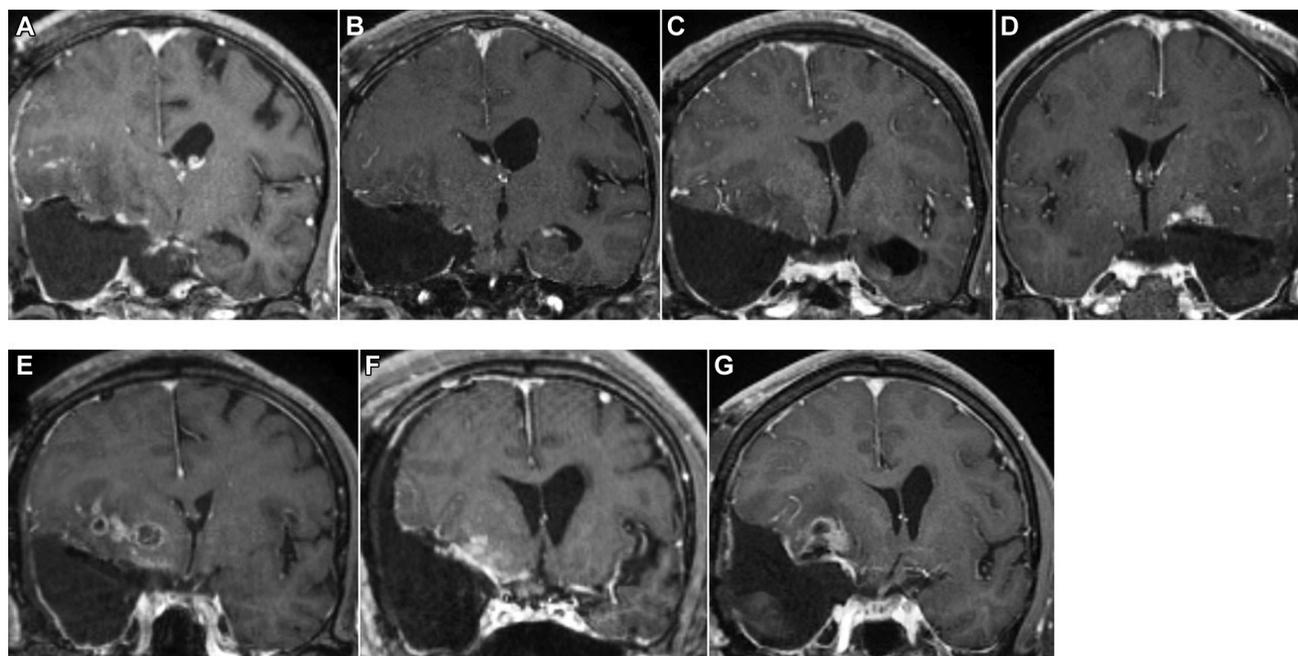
Postoperative coronal gadolinium-enhanced T1-weighted magnetic resonance imaging of 7 cases of medial temporal glioblastomas. (A–G) Cases 1 to 7, respectively. (A–D) Mimicking type allowing extensive resection and opened temporal horn on the resection side appearing as high as the contralateral temporal horn. Case 4 (D) showed
